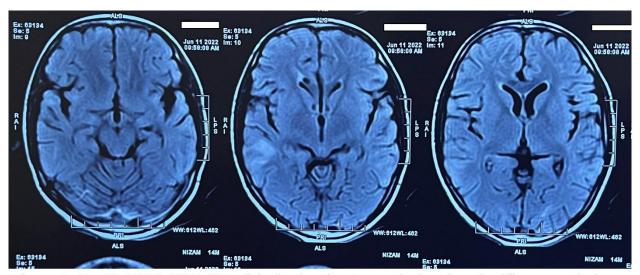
A,B,C are Axial section T2 FLAIR Images of brain showing hyperintense signal involving cortical and subcortical regions of bilateral frontal, parietal and temporal lobes
